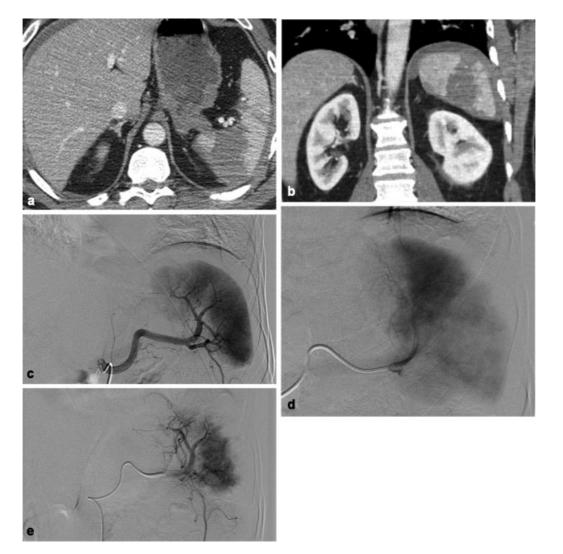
A 50-year-old man who fell from 20 feet. (a) Axial CT of the abdomen and (b) coronal CT of the abdomen showing extensive splenic contusion/laceration with perisplenic hematoma consistent with a grade IV injury. (c) Early-phase splenic angiography. (d) Late-phase splenic angiography demonstrating multiple segmental perfusion defects, correlating to known splenic lacerations. Faint petechial contrast pooling in the region of the parenchymal defect. (e) Postembolization angiography following Gelfoam embolization from the distal main splenic artery with resultant sluggish flow and peripheral vascular pruning.
